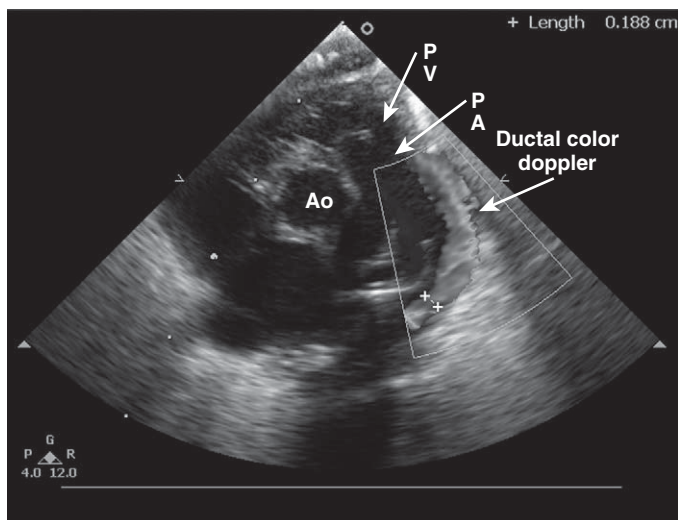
■ Short axis parasternal with left to right ductal flow seen in orange. Ao, Aorta; PA, pulmonary artery; PV, pulmonary valve.
